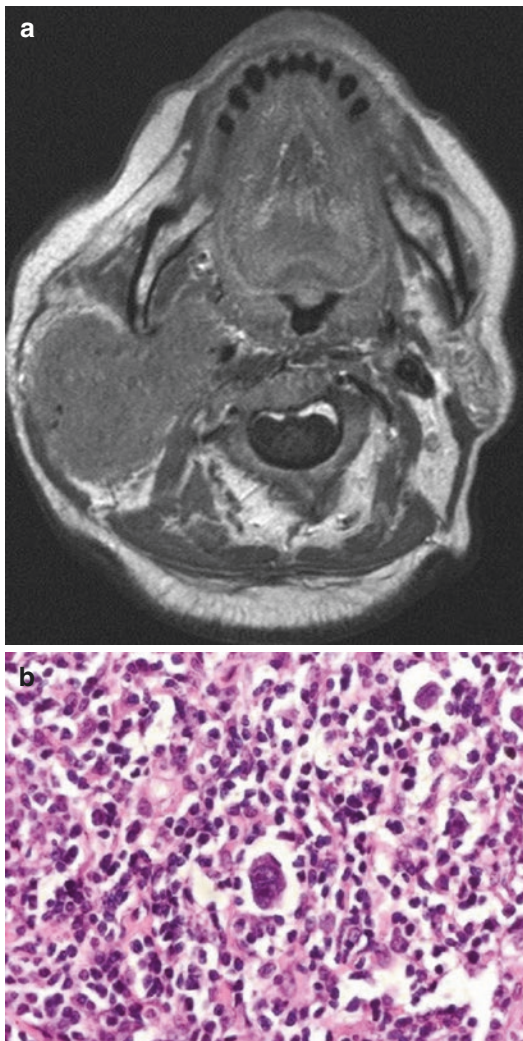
T1-weighted MRI of a patient with Sjögren's syndrome who experienced rapid growth of the right parotid (a). Subsequent biopsy confirmed a mass of monoclonal lymphocytes consistent with lymphoma (b) (Image courtesy of M. Boyd Gillespie, MD)
